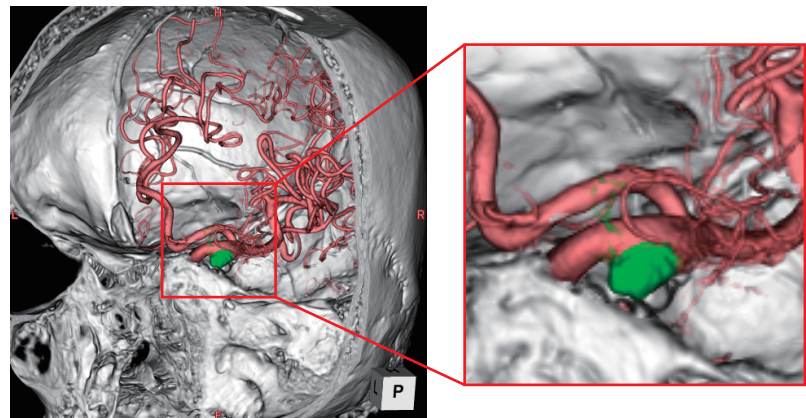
Fusion Image Showing the Right Internal Carotid Artery (3D-DSA) and the Skull (SCORE CT) of a Patient with a Brain Aneurysm
